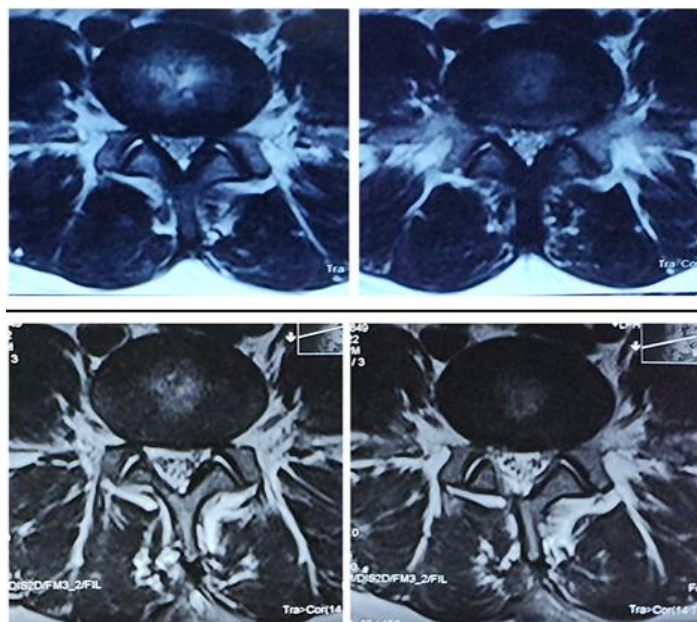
Spine MRI of a 33-year-old female. The top MRI shows L4-L5 stenosis preoperatively and the bottom MRI shows the postoperative decompression through right ULBD.
